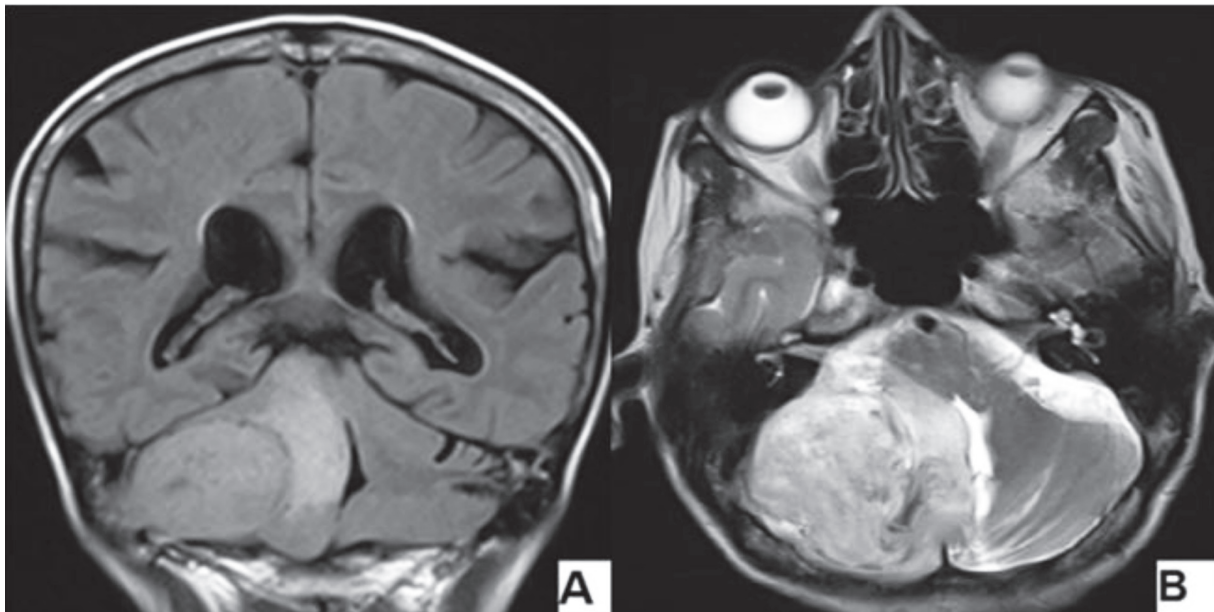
Preoperative magnetic resonance imaging (MRI) performed in last year control before surgery of RIM. (A): Preoperative coronal T2-weighted fluid-attenuated inversion recovery (FLAIR) MRI showing a tumor of right CPA that measures 5.5x7x3 cm. (B): Preoperative axial T2-weighted MRI. Note that there are two compartments showed different contrast enhancing.
